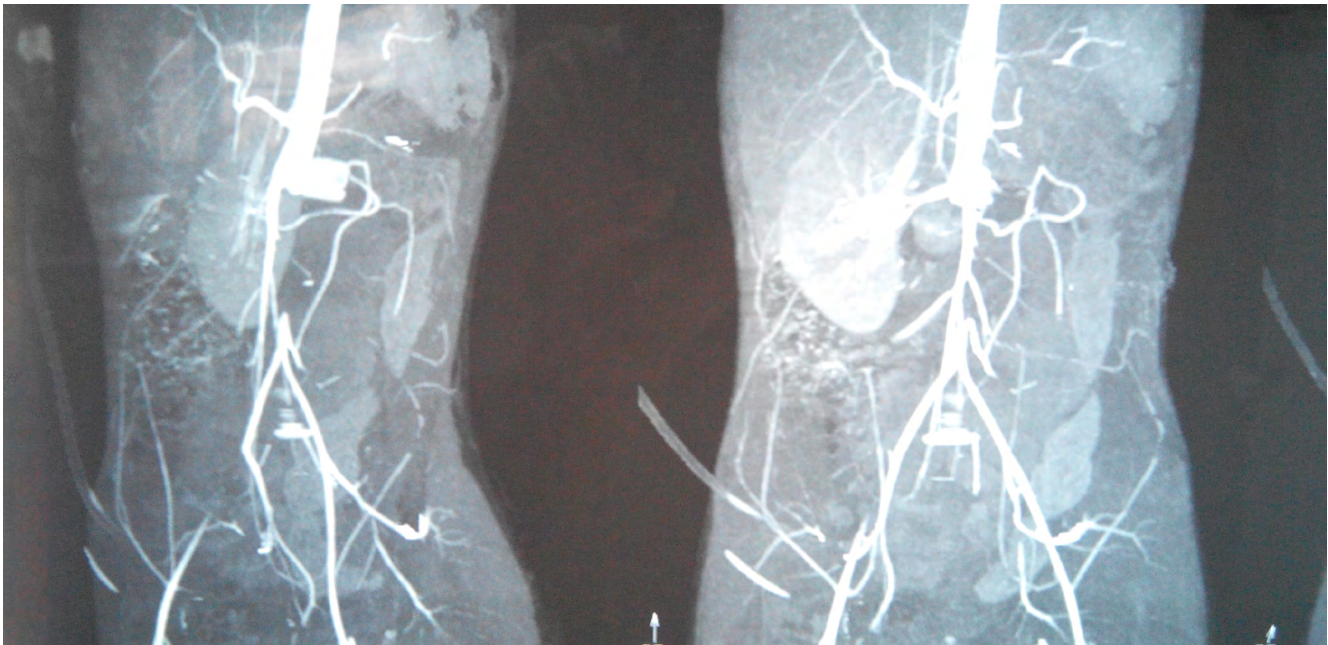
Pre and post operative computed tomography (2a) preoperative CT Shows an abrupt termination of the aorta below the right renal artery (2b) post operative CT shows normal blood flow.
